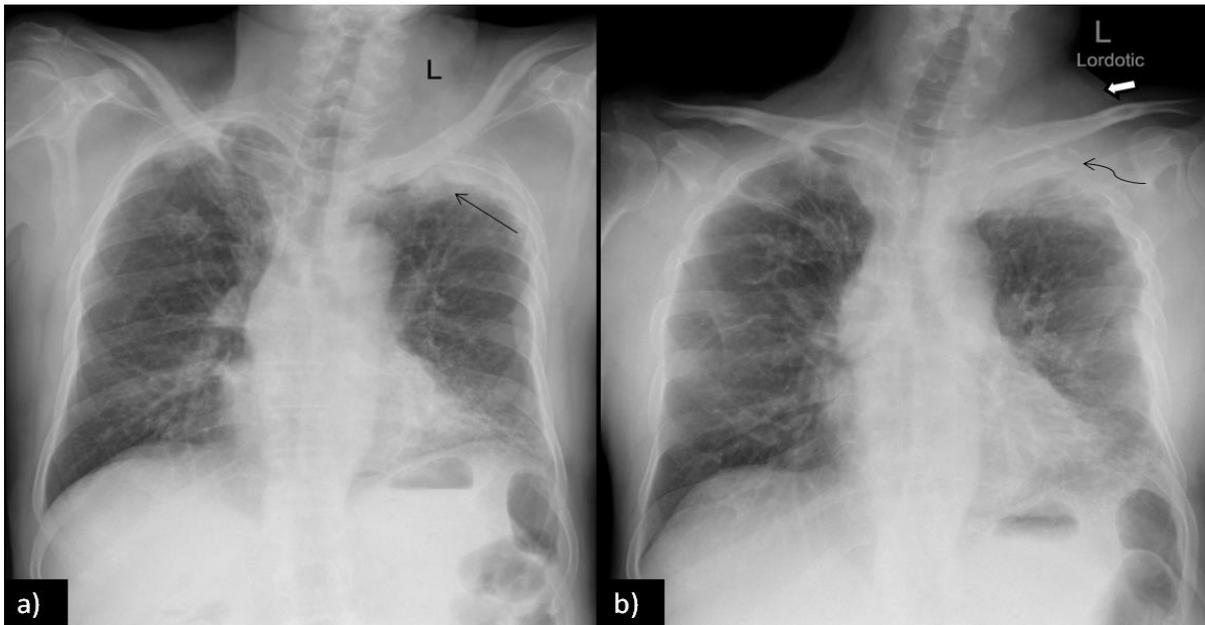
(a and b): Frontal Chest radiograph (PA and Lordotic view) – Left irregular apical cap thickening(straight arrow) with adjacent bone destruction of 1st-3rd ribs(curved arrow) and cervical soft tissue component(block arrow). Linear and reticular opacities are seen in right upper and left lower zone.
